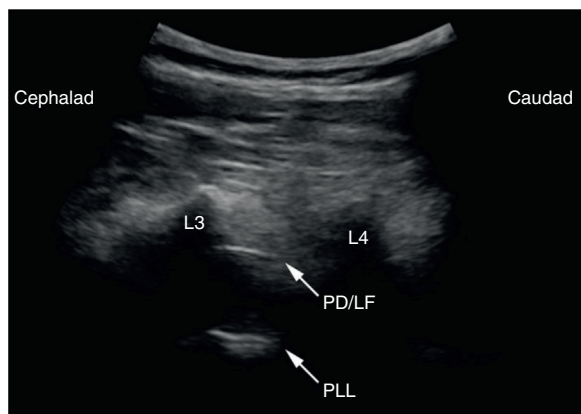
Paramedian longitudinal ultrasound image showing Ligamentum Flavum (LF), Posterior Dura (PD) and the Posterior Longitudinal Ligament (PLL), at the interspace of L3 and L4.
